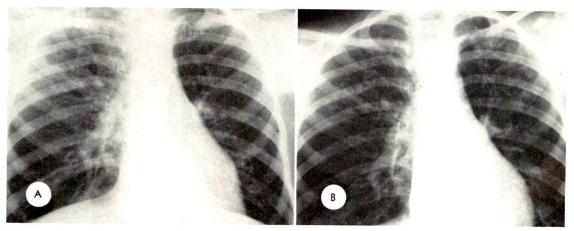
Chest roentgenograms of a boy with chronic and repeated respiratory infections. (A) When first seen at 13 years of age, there was at electasis of the left lower lobe visible behind the heart. (B) A year later, in spite of intensive effort directed to the respiratory passages, the atelectasis was unchanged.
